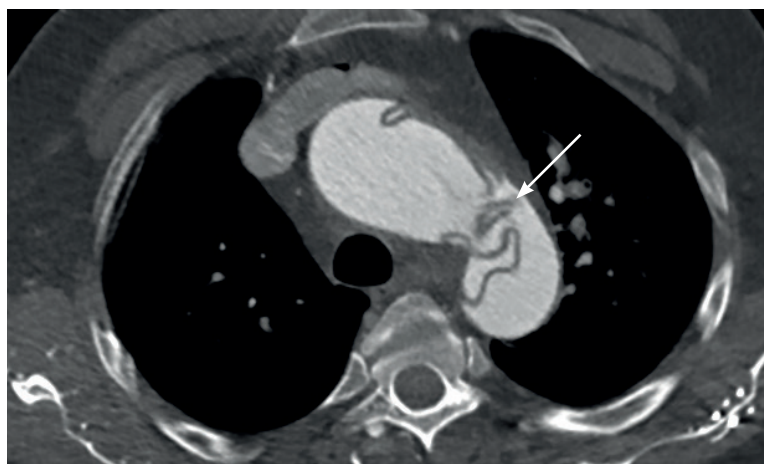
Axial section of a computed tomography angiogram through the aortic arch showing the ribbon-like filling defect consistent with a dissection flap (arrow).
